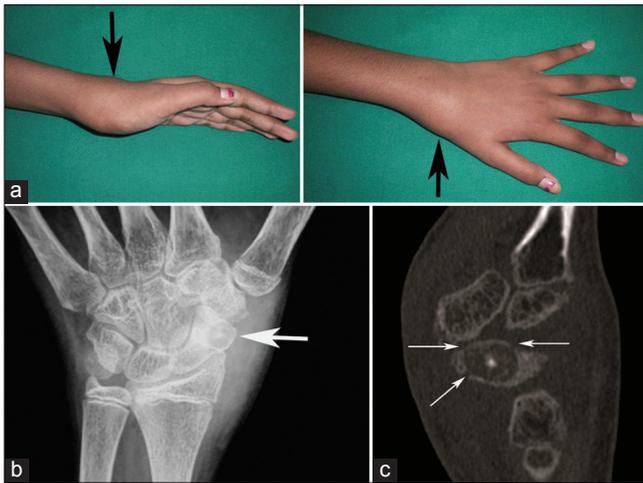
(a) Clinical photograph showing swelling at the dorso-radial aspect of the wrist (arrow). (b) Radiograph of the wrist showing an osteolytic lesion at the distal radial corner of the scaphoid with a central nidus. (c) The CT scan of the wrist showing lytic lesion with a nidus in the center. The arrows show the sites of cortical perforations (white arrow)
